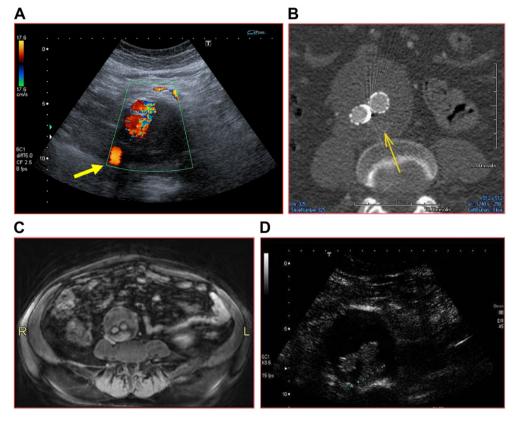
Figures summarizing the findings according to four different imaging methods of a type II endoleak after endovascular repair of an abdominal aortic aneurysm: A) Colour-Doppler ultrasound: no flow signal is detected within the aneurysm sac (arrow indicates a hypertrophic lumbar artery); B) computed tomography angiography: no focal contrast-enhancement within the aneurysm sac (arrow indicates the place where the endoleak is not evident due to artefacts; C) magnetic resonance angiography and D) contrast-enhanced ultrasound: focal contrast-enhancement behind the iliac branches during arterial phase consistent with endoleak.
